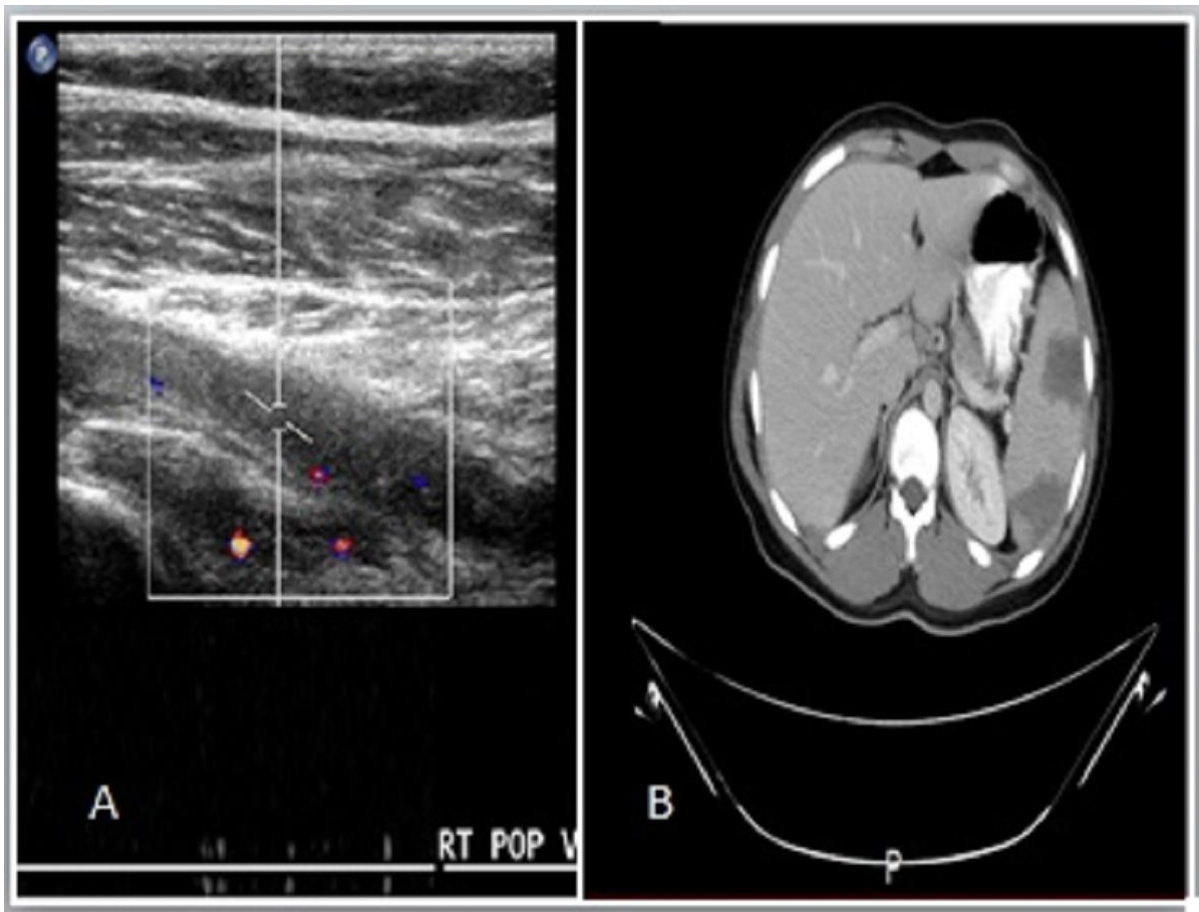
A. Doppler USG of right popliteal fossa showing thrombus filling popliteal vein with absence of color filling. B.CT scan of the abdomen showing large splenic wedge shaped hypodensities consistent with splenic infarcts.
